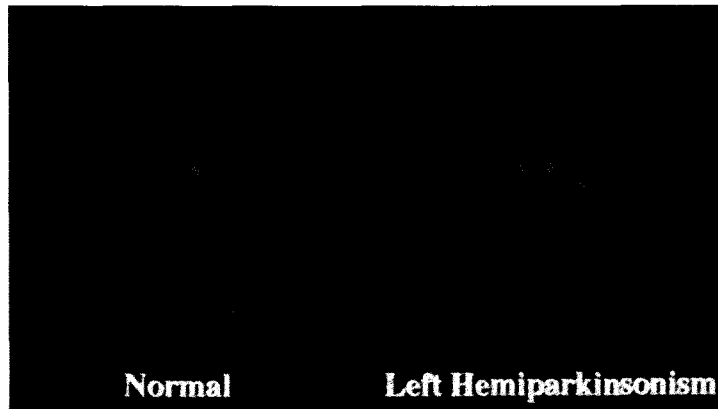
[^{123}I] β -CIT SPECT images of a healthy subject and of a patient with hemiparkinsonism. In the patient with hemiparkinsonism, [^{123}I] β -CIT binding is reduced not only in the striatum contralateral to the clinical symptoms but also in the ipsilateral striatum. Note that left is on the right in the figure.
